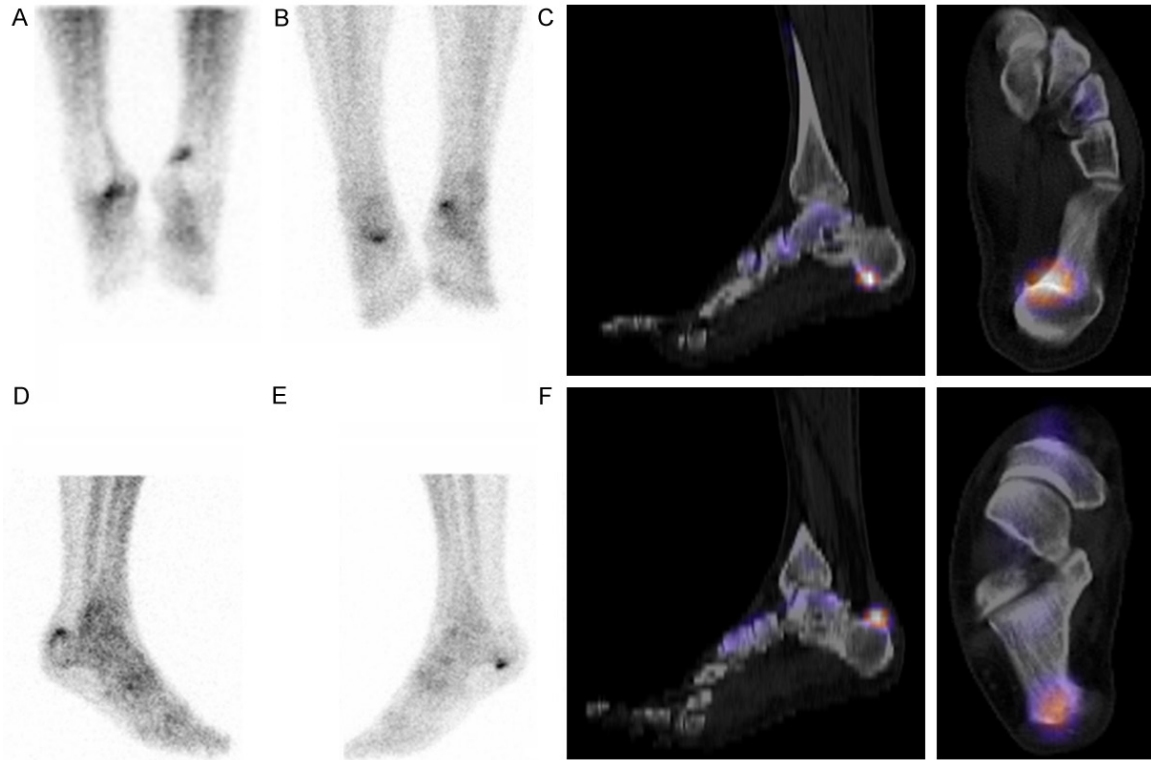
Posterior blood pool image (A) shows hyperemia in the posterior aspect of the right calcaneus and plantar aspect of the left calcaneus. Delayed posterior (B) and lateral images of the right (D) and left (E) foot demonstrate increased uptake in a similar distribution. Sagittal and axial SPECT-CT images of the left foot (C) demonstrate increased activity at the calcaneal tuberosity consistent with plantar fasciitis. Sagittal and axial SPECT-CT images of the right foot (F) show increased uptake at the Achilles' insertion site in the calcaneus, consistent with Achilles enthesopathy.
